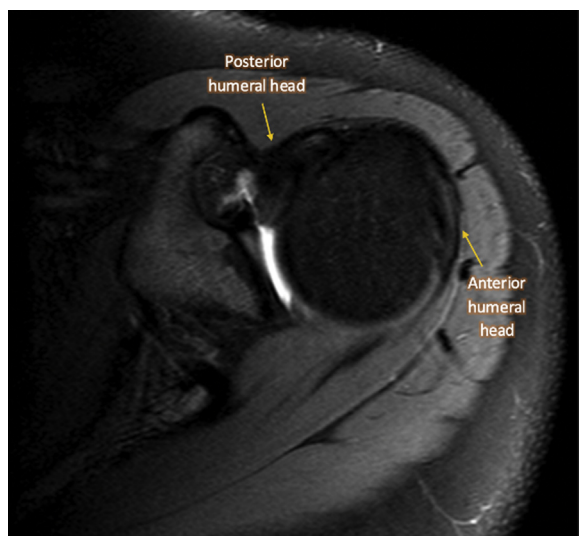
Preoperative axial magnetic resonance image of the operative left shoulder depicting posterior subluxation of the humeral head relative to the glenoid without a labral tear.
